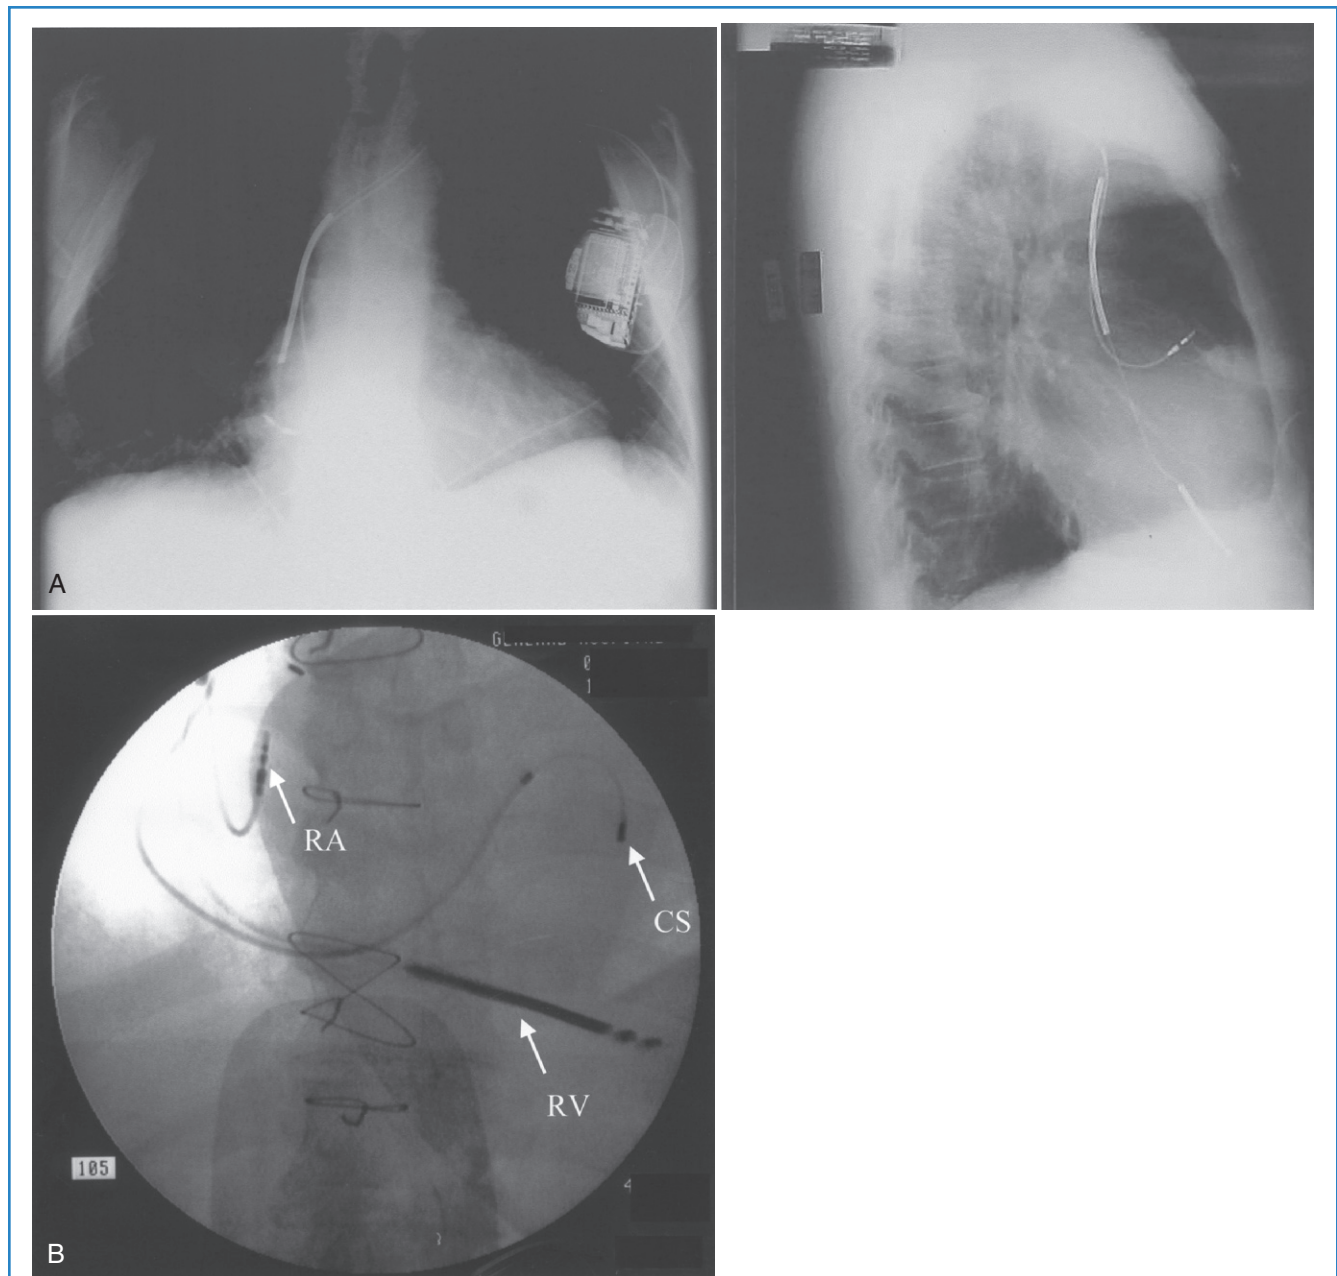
Different types of dual-chamber implantable cardioverter-defibrillator (ICD) systems. A, Posteroanterior and lateral chest radiographs of dual-chamber ICD with right atrial pacing and sensing lead and right ventricular pacing and defibrillation lead. B, Fluoroscopic view of biventricular ICD demonstrating pacing lead in coronary sinus (CS) in addition to right atrial (RA) and right ventricular (RV) pacing, defibrillation leads, or both.
